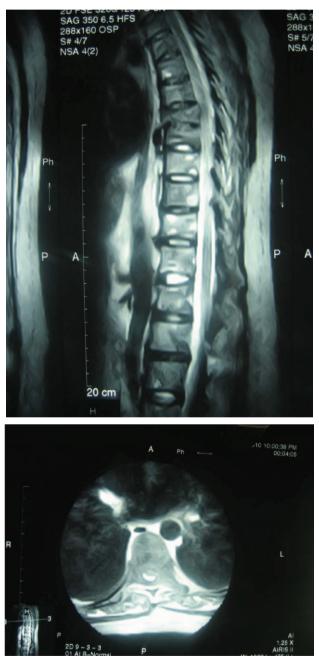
Sagittal (A) and cross-sectional (B) T2-weighted magnetic resonance imaging of the thoracic spine showing abnormal high-signal and compression fractures of the 7th and 8th thoracic vertebral bodies, causing cord compression. These lesions corresponded to metastatic disease.
